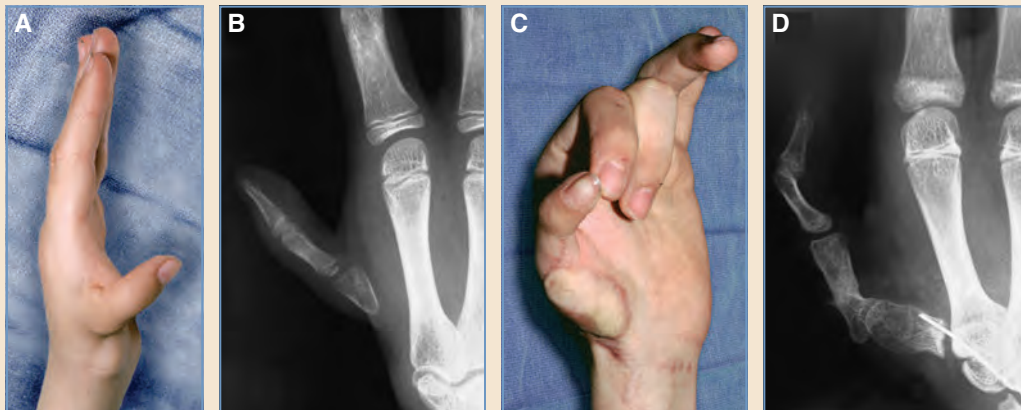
Type IIIB microvascular reconstruction. A and B, Clinical photograph and radiograph showing a type IIIB thumb hypoplasia in which there is no proximal metacarpal and CMC joint. This thumb has no skeletal attachment to the rest of the hand. C and D, A second toe metatarsophalangeal joint, with a covering soft tissue flap, was transferred to provide the skeletal connection and stability. The clinical photograph is shown at skeletal maturity. Tendon transfers were needed to provide extrinsic flexion and extension to the thumb, and the skin flap helped build up the thenar region. (Courtesy of G. Fouchet, MD.)
